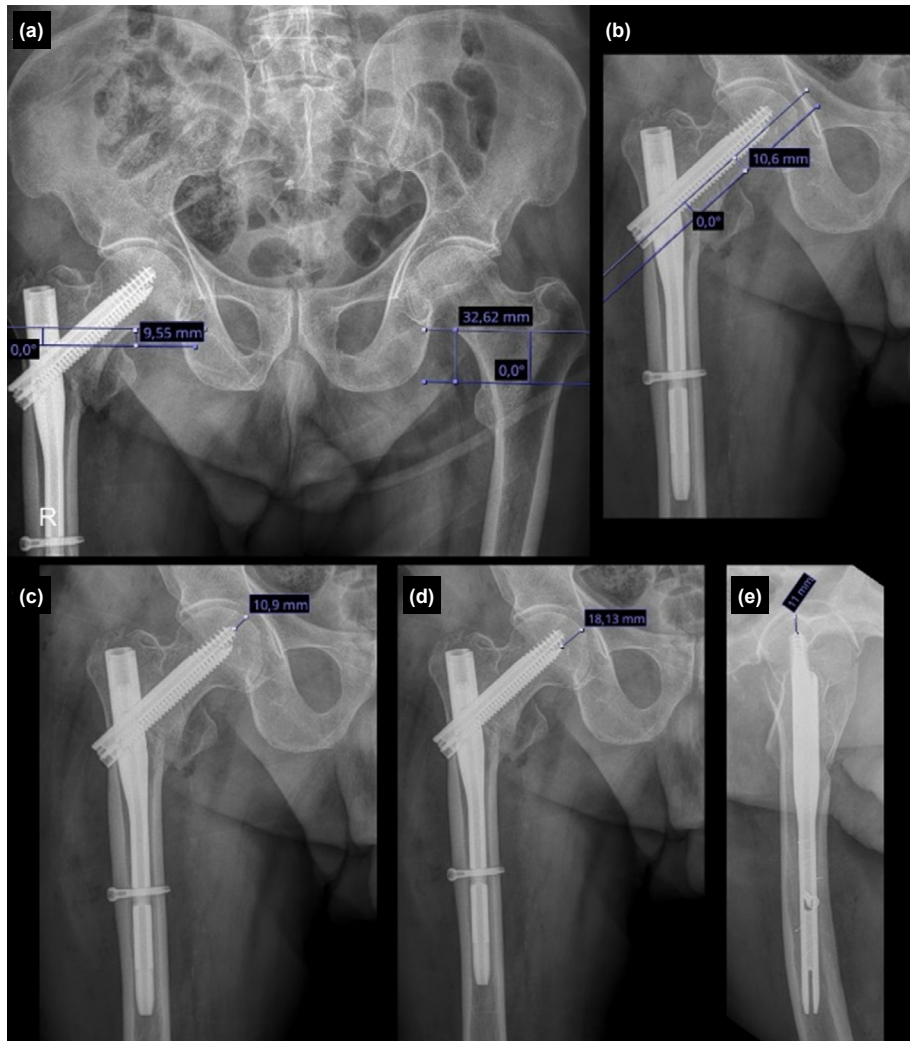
Radiographic measurements for the integrated intertrochanteric antegrade nail (InterTAN) type proximal femoral nail (PFN). (a) Trochanter minor-calcar distance and normal-side trochanter minor-calcar distance; (b) Anteroposterior distal lag screw-calcar distance (ApLAG2-calcar distance); (c) Anteroposterior proximal lag screw tip-head distance (ApLAG1); (d) ApLAG2; (e) Lateral tip-apex distance (LatTAD).
